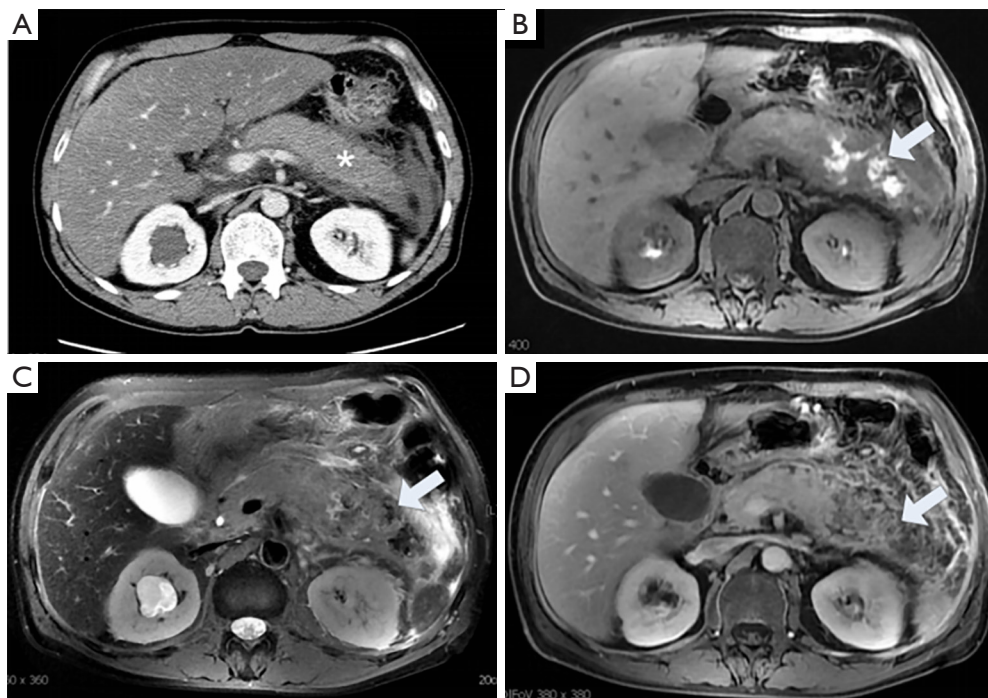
A 55-year-old male with acute necrotizing pancreatitis. On the first day after onset, the enhanced CT image (A) showed enlargement of the body and tail of the pancreas, collections of peripancreatic fluid, and homogeneous enhancement of the pancreatic parenchyma (asterisk). However, on the 9th day after onset, the abdominal MRI T1WI (B, arrow) and T2WI (C, arrow) showed patchy hyper/hypo-intensity, which refers to pancreatic hemorrhages, and a large slightly hypo-/hyperintensity area represented necrosis. After enhancement (D), large nonenhancement areas are found in the body and tail of the pancreas and peripancreas (arrow). MRI, MR imaging.
